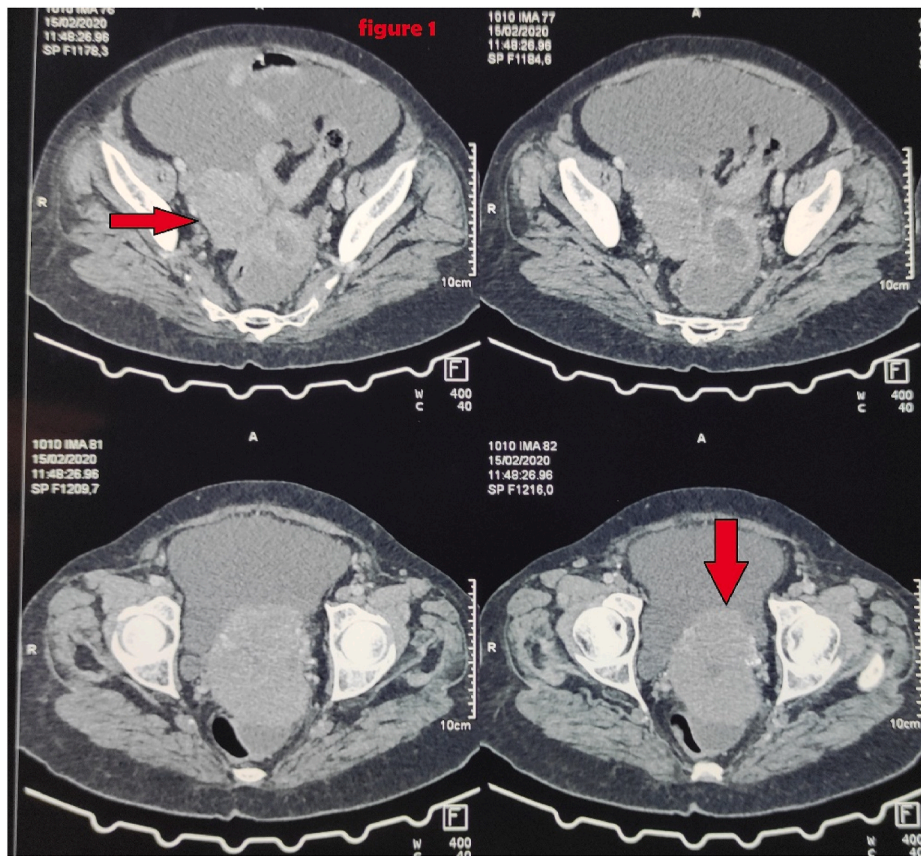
Enhanced abdomino-pelvic computed tomography scan showed a right pelvic ovarian mass measuring 110 × 84 × 82mm (arrow).
